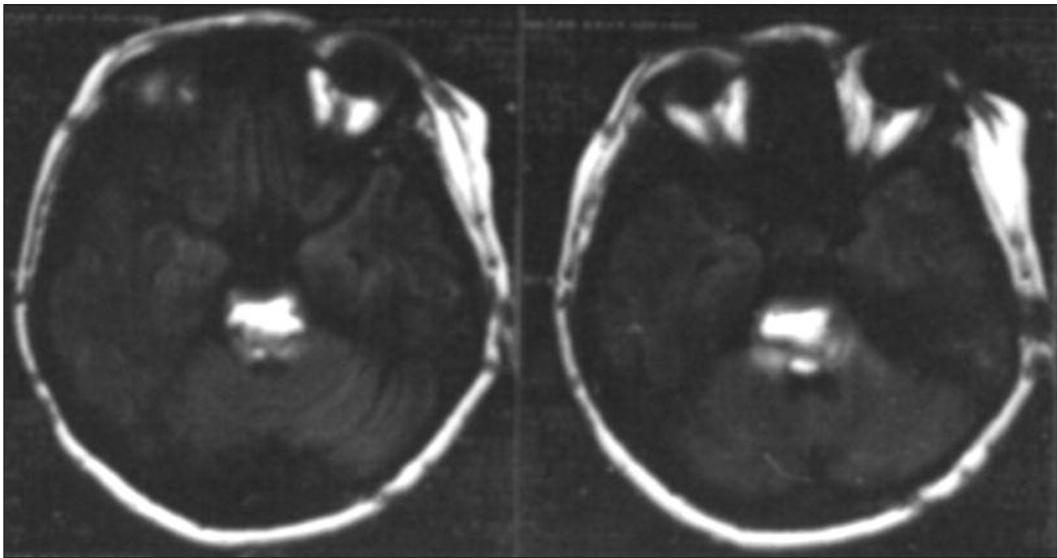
Diagnostic images of patient. Cranial FLAIR weighted MRI images show large (2x1 cm in diameter), hyperintense lesion in the bilateral basal-ganglia pontine area.
